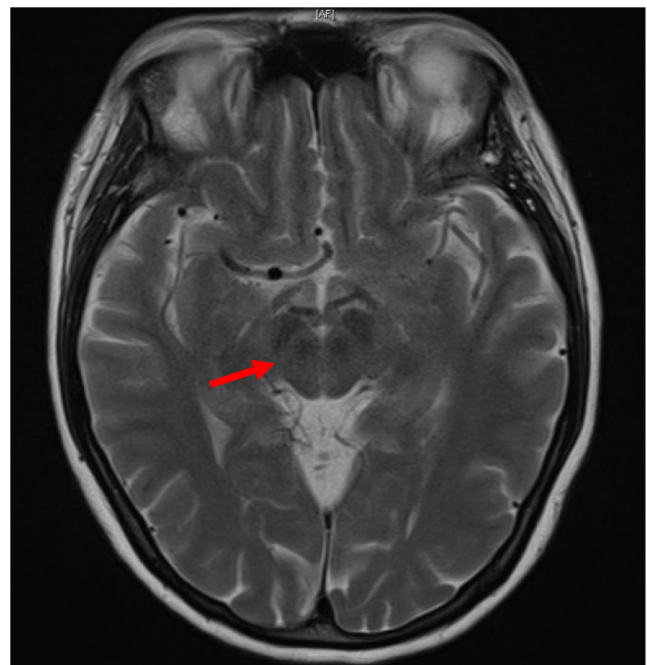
T2 magnetic resonance imaging (MRI) visualized increased densities in basal ganglia with the characteristic 'face of the giant panda'.
